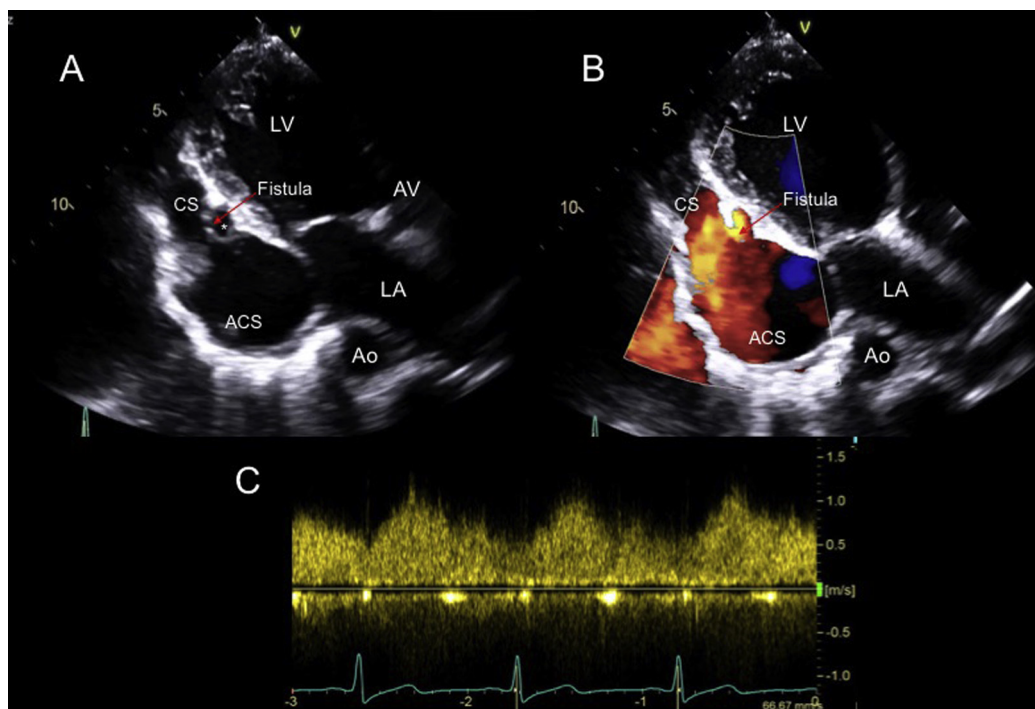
(A) Two-dimensional transthoracic apical long-axis view shows the dilated LCx (asterisk) draining into a dilated coronary sinus (CS, arrow). (B) Color Doppler echocardiography from the same view shows abundant and turbulent blood flow draining into the CS from the coronary artery fistula. (C) Continuous-wave Doppler demonstrates the continuous flow into the CS with a peak velocity of 1.1 m/sec. ACS, Aneurysmal coronary sinus; Ao, aorta; AV, aortic valve; LA, left atrium; LV, left ventricle.
